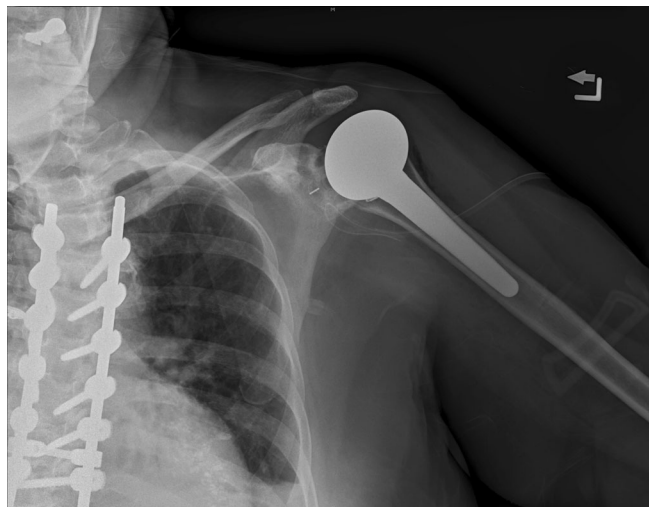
This AP radiograph of the left shoulder documents satisfactory alignment and position of both the cemented glenoid component and the cementless humeral implant.
